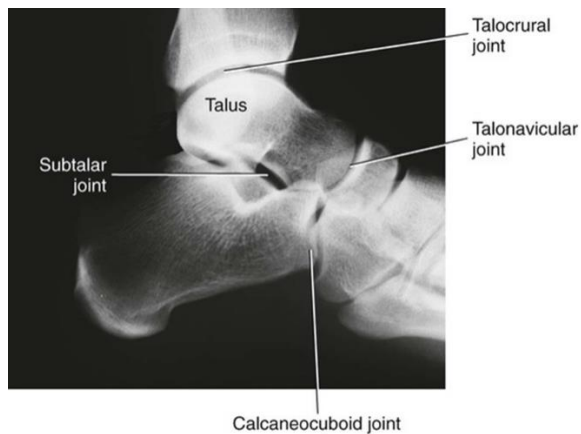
The radiograph of a healthy right the proximal joints of the ankle and foot[23]
